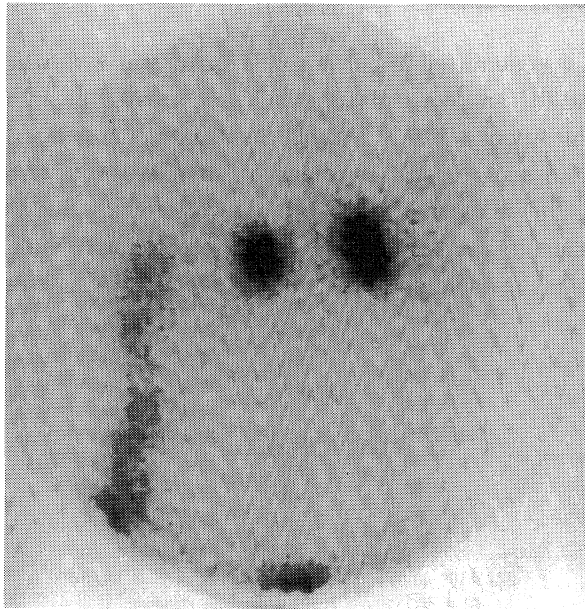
Adrenal scintigram showed bilateral strong uptake of  $^{123}\text{I}$ -Adosterol
